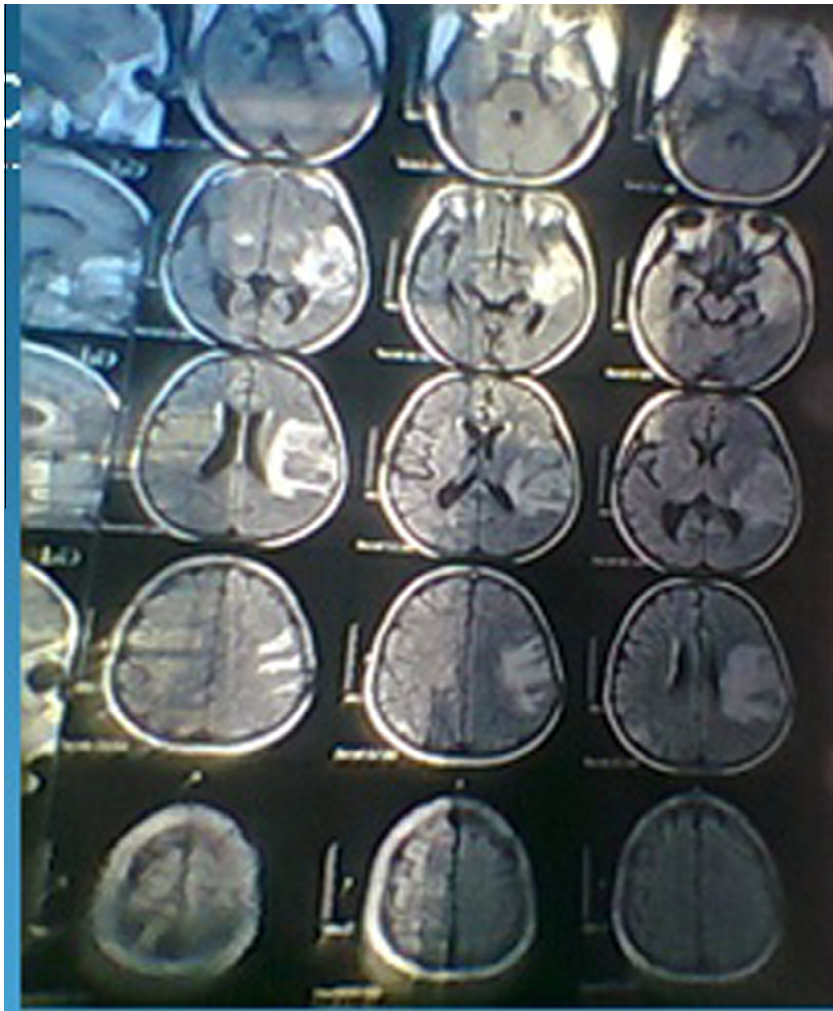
MRI brain showed tumor correlated with astrocytoma.
